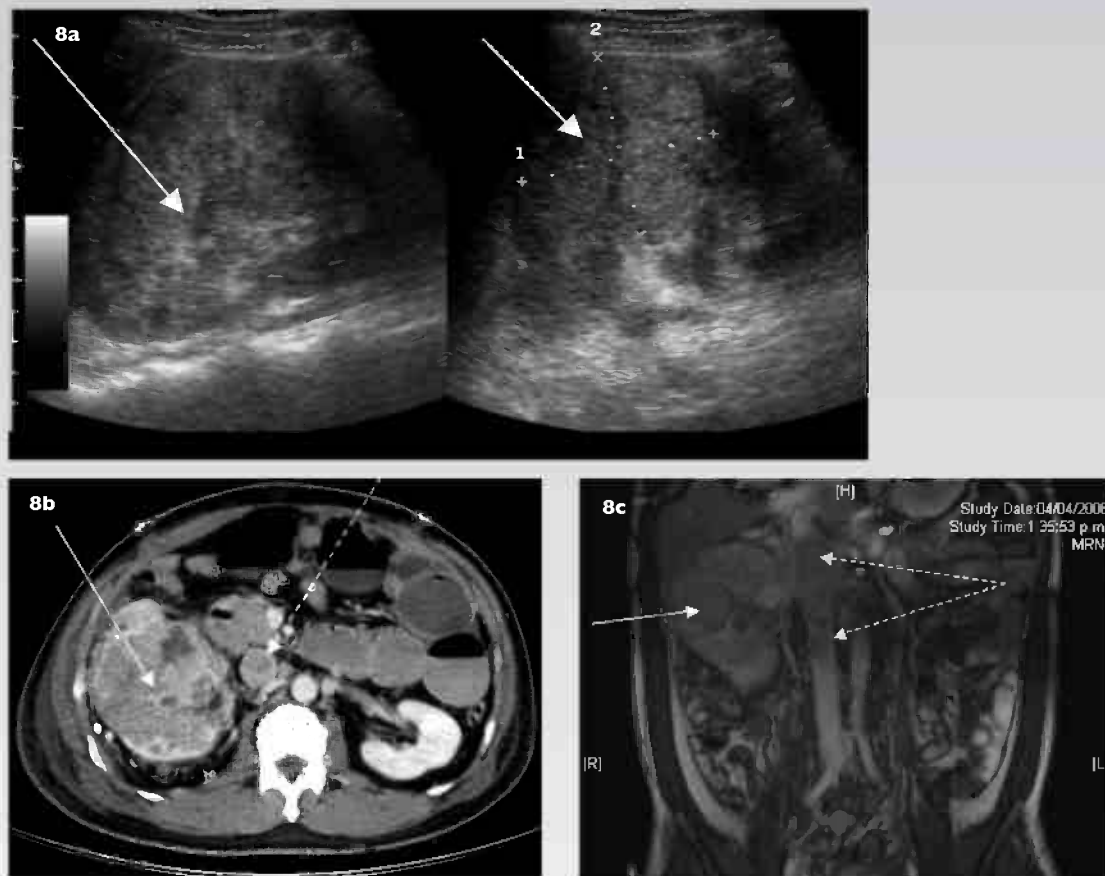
(a) US images show a large renal mass (arrows) in the right kidney in a man who presented with gross haematuria. (b) Corresponding axial CT image shows the large RCC (arrow) with tumour thrombus (dashed arrow) causing a filling defect in the IVC. (c) Coronal MR image shows the RCC (arrow) as well as extensive tumour thrombus (dashed arrow) in the IVC.
